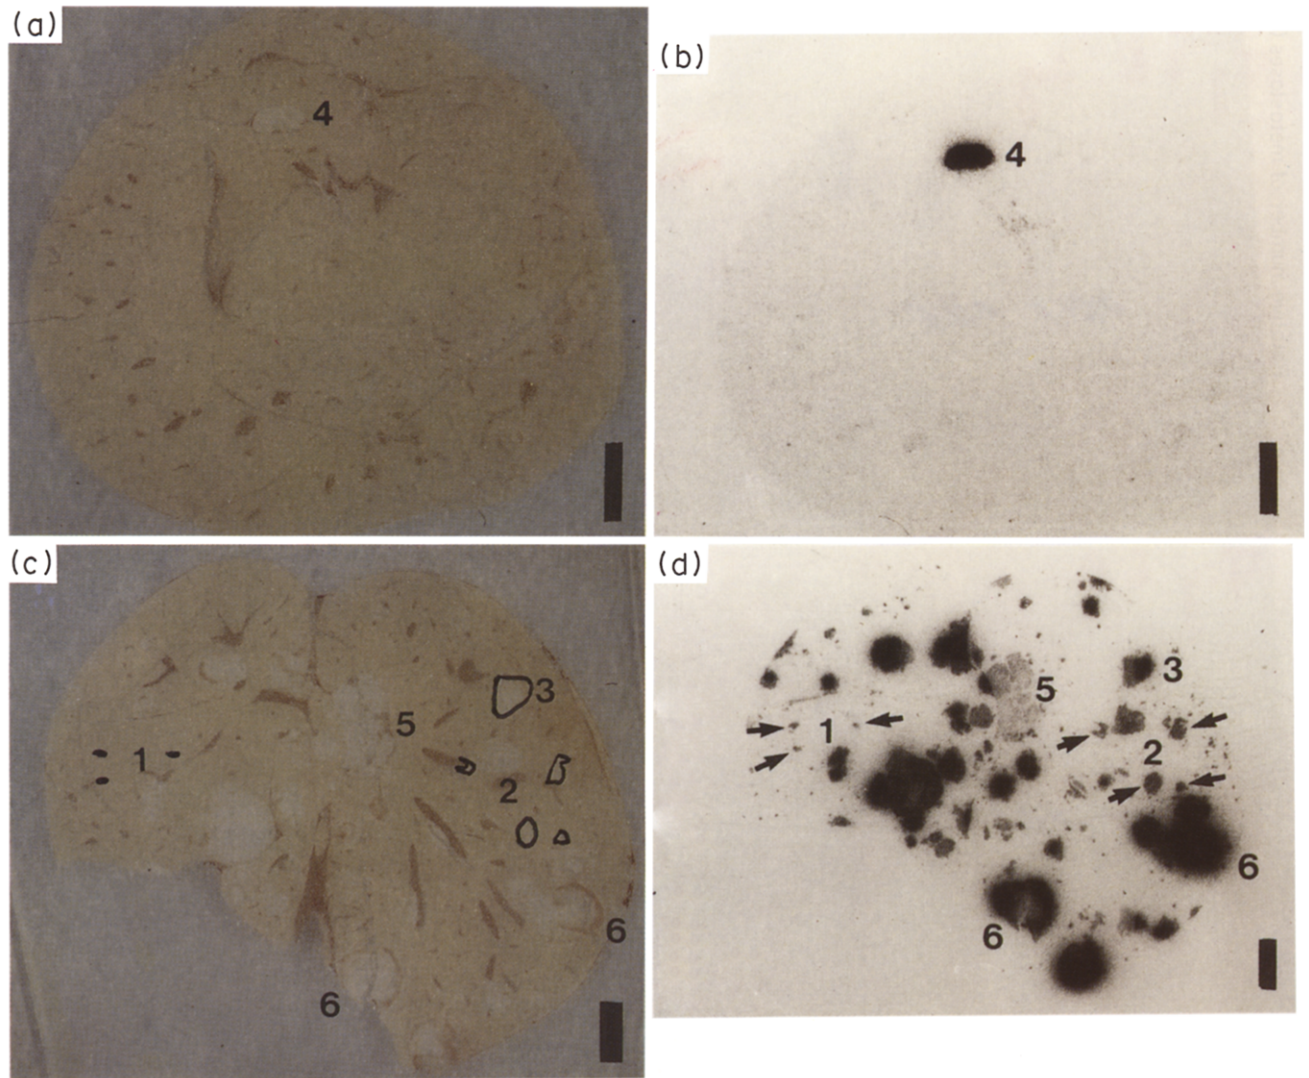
Autoradiographic visualisation of metastases in individual liver samples. (a), (c) Lyophilised liver sections, unstained. (b), (d) Corresponding autoradiographs (X-ray films prior to any processing). Large vessels (dark brown structures) and large metastases (pale areas) are clearly visible in the sections, while faintly visible lesions are encircled by black lines. Clearance of radioactivity out of the blood was virtually complete as corresponding areas in the autoradiographs showed background density. Typical metastatic lesions and corresponding spots on X-ray images are identified by numbers which relate to the following categories: 1, 2, 4, small, intermediate size, large metastases with uniform uptake; 3, large size metastasis showing a gradient uptake; 5, large metastasis, low uptake; 6, large metastases, highly non-uniform uptake. Arrows are pointing to several representatives of the small (left-hand side of autoradiograph) and the intermediate size category (2; right-hand side).
